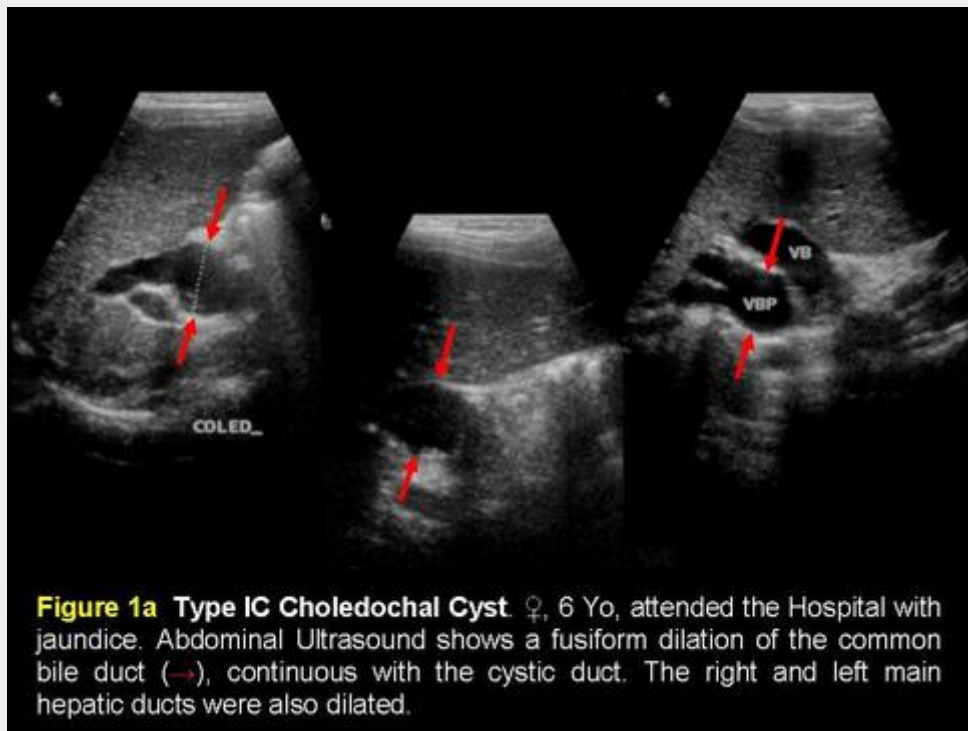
Type IC Choledochal Cyst. ♀, 6 Yo, attended the Hospital with jaundice. Abdominal Ultrasound shows a fusiform dilation of the common bile duct (→), continuous with the cystic duct. The right and left main hepatic ducts were also dilated.
